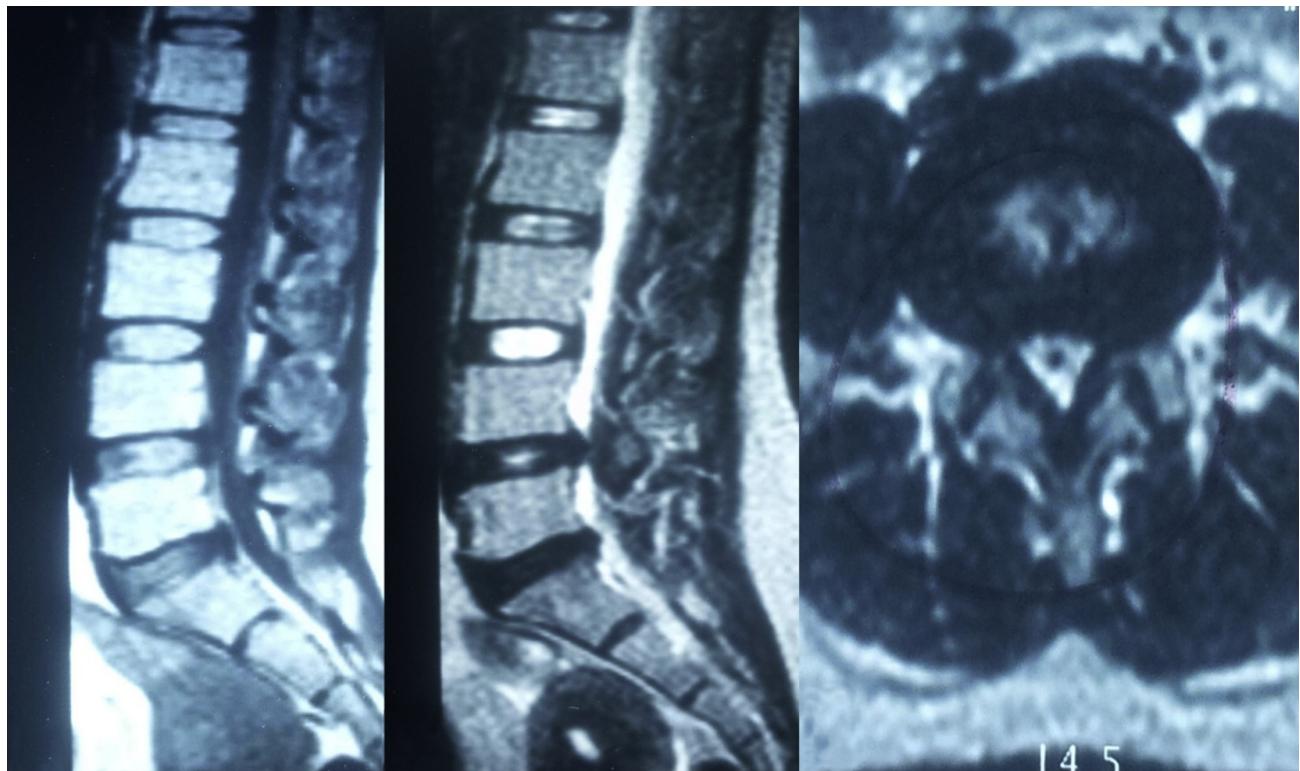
Magnetic resonance images of lumbosacral spine before L4–L5 laminectomy (Left) sagittal T1W (Middle) sagittal T2W (Right) axial T2W.
